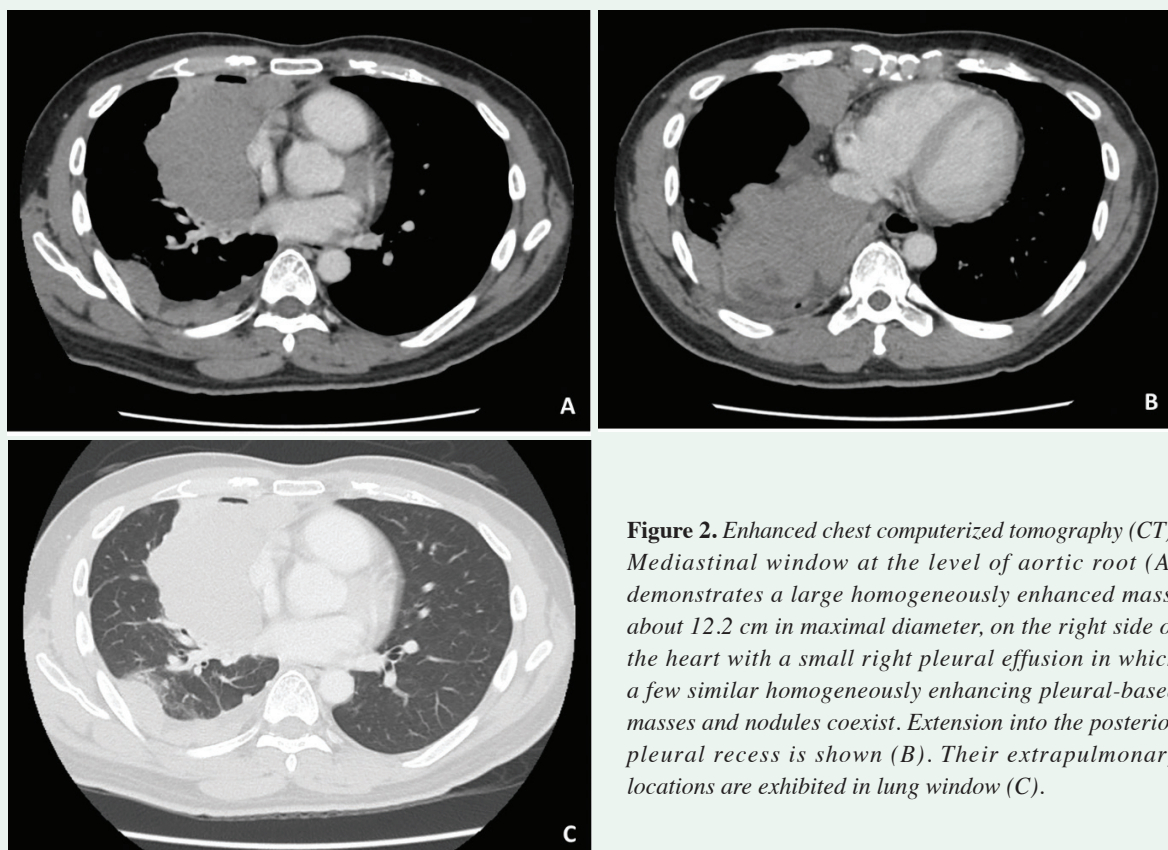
Enhanced chest computerized tomography (CT). Mediastinal window at the level of aortic root (A) demonstrates a large homogeneously enhanced mass, about 12.2 cm in maximal diameter, on the right side of the heart with a small right pleural effusion in which a few similar homogeneously enhancing pleural-based masses and nodules coexist. Extension into the posterior pleural recess is shown (B). Their extrapulmonary locations are exhibited in lung window (C).
